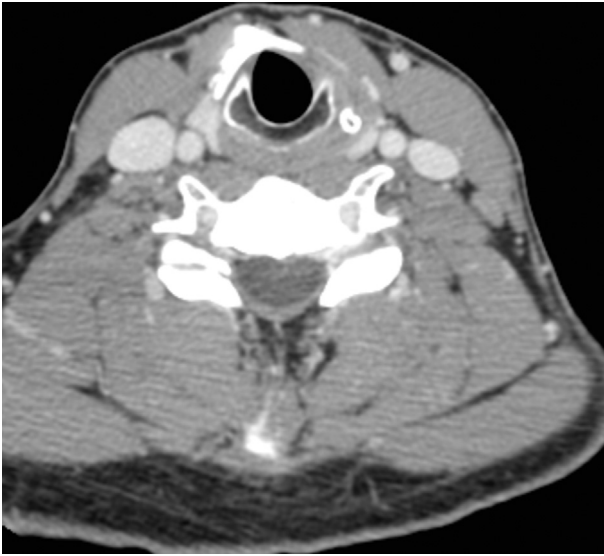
CT scan after 6 months.
